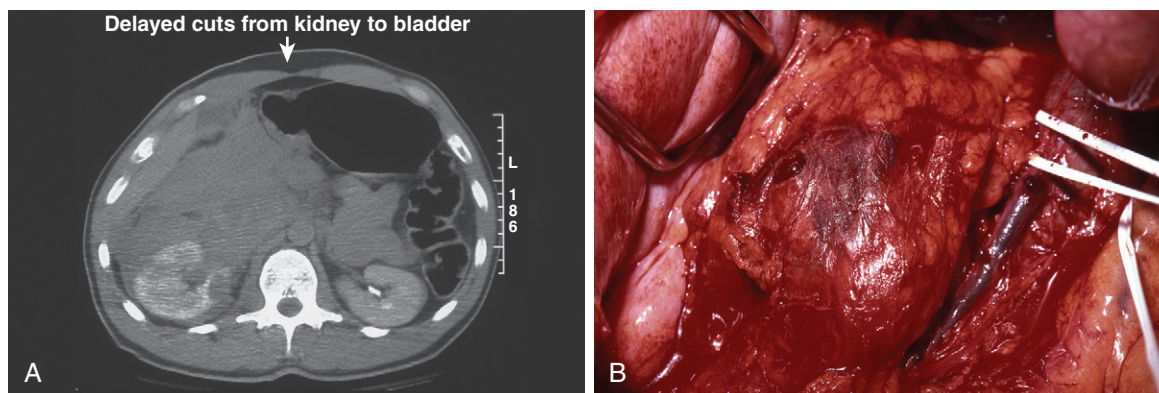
A, Computed tomography, right perirenal hematoma. B, Right perirenal hematoma. (Courtesy of Jack W. McAninch, MD.)
